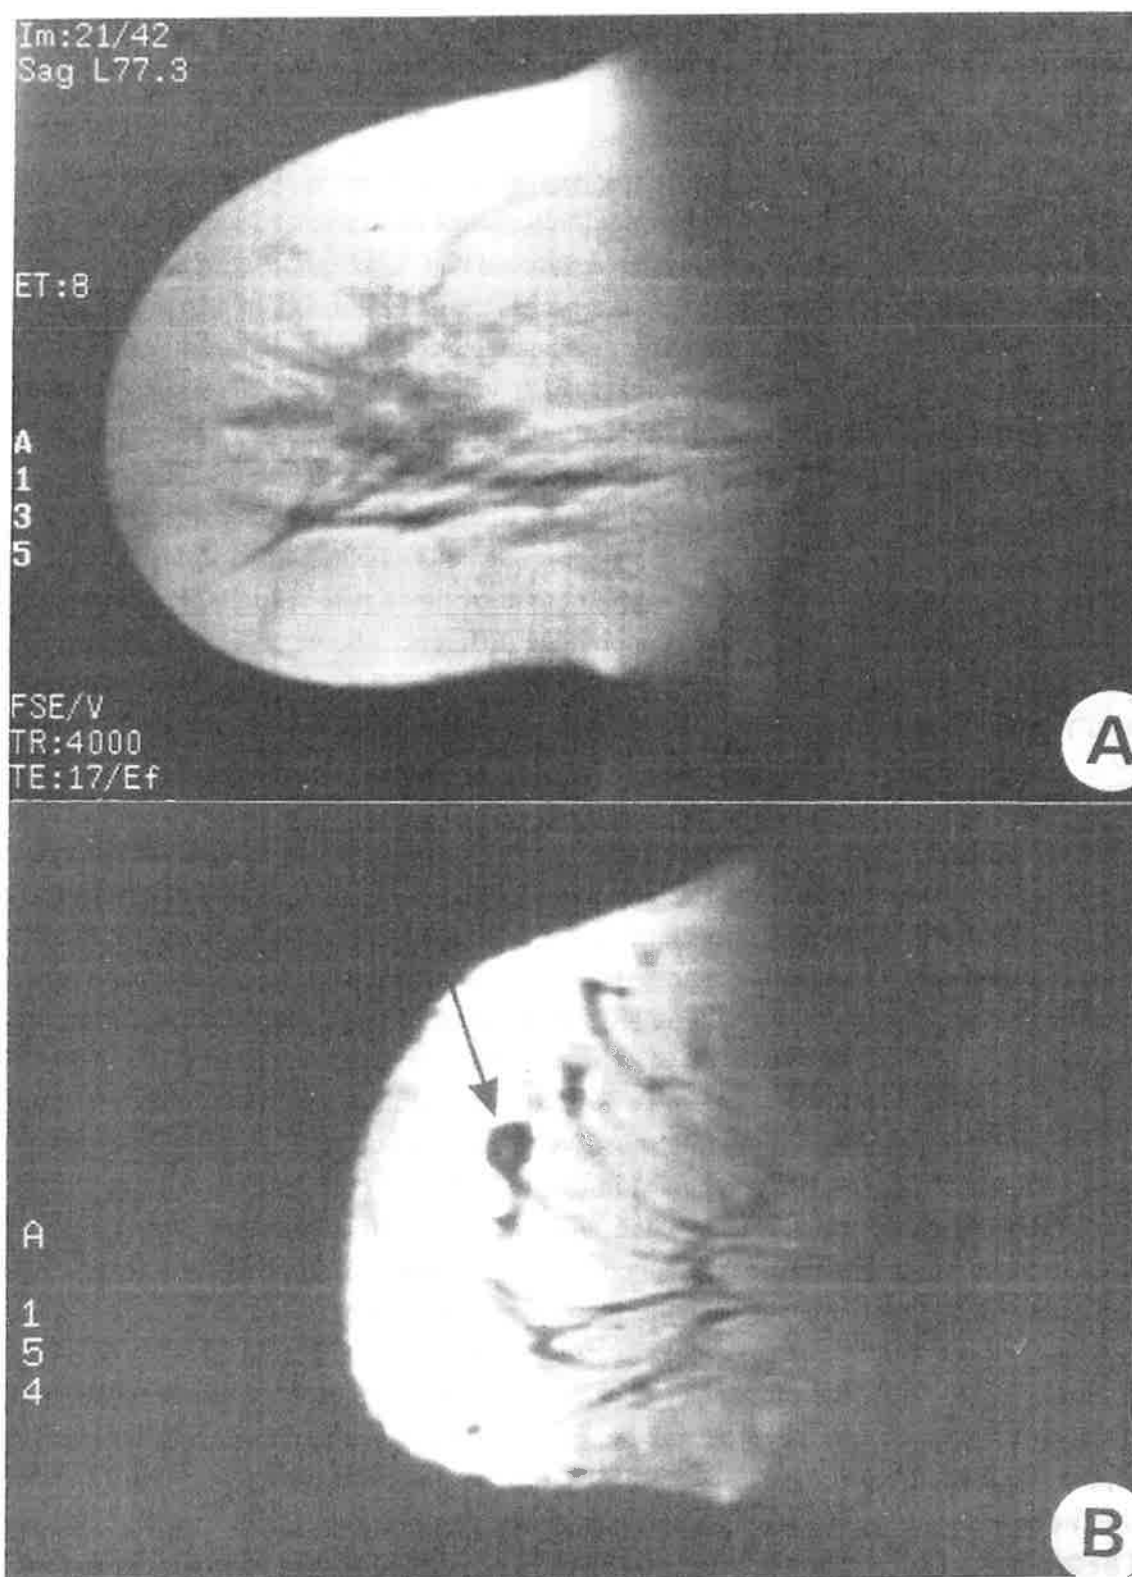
MRI breast examination of a middle-aged patient. A. T₂-weighted MR image of a normal involuted breast (right), acquired with a fast spin-echo sequence (sagittal view, TR = 4000 msec, TE = 17 msec); B. MR image of the left breast of the same patient, demonstrating a nonspecific nodule in an involuted breast (arrow). This image was acquired with a gradient-recalled echo sequence (SPGR) (sagittal view, TR = 150 msec, TE = 3.3 msec).
